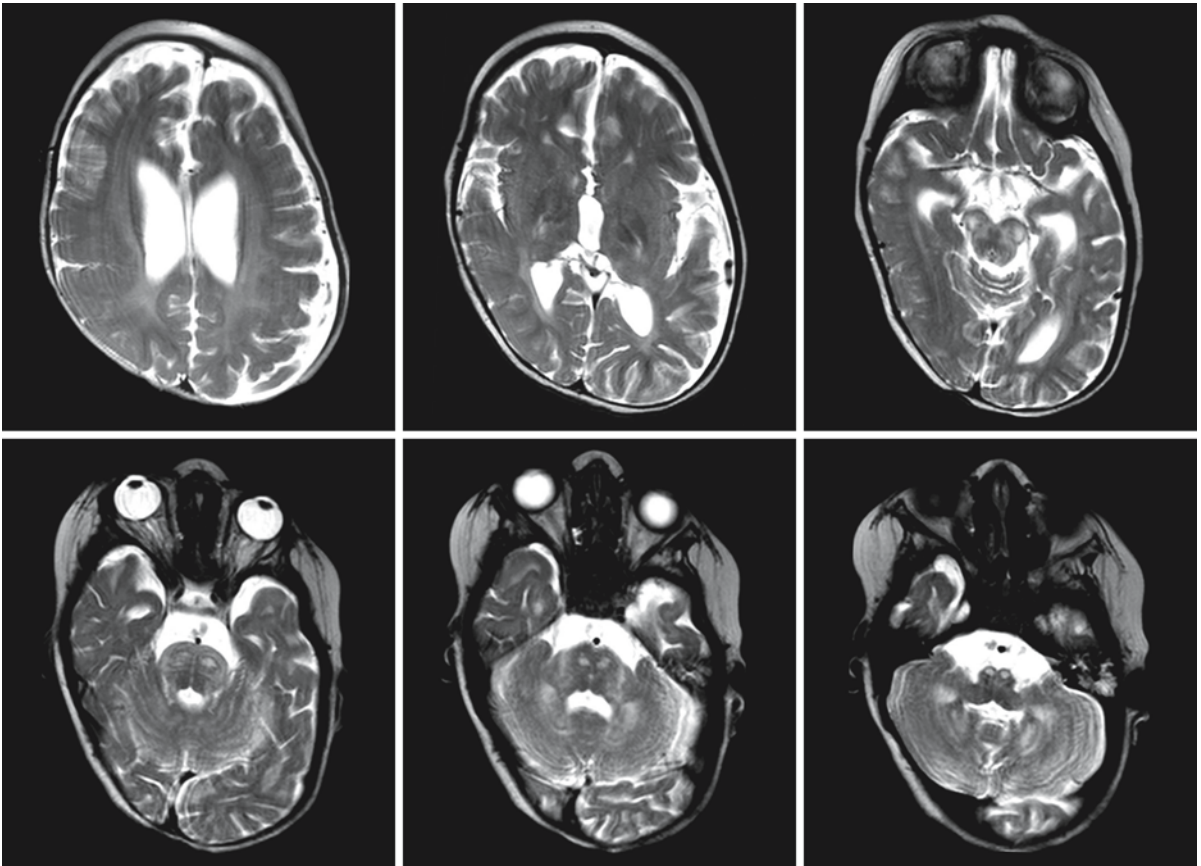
Follow-up MRI of the same boy with BPD at the age of 26 months, shortly before he died. The process of demyelination now involves the brain stem more extensively. The posterior limb of the internal capsule and posterior cerebral
